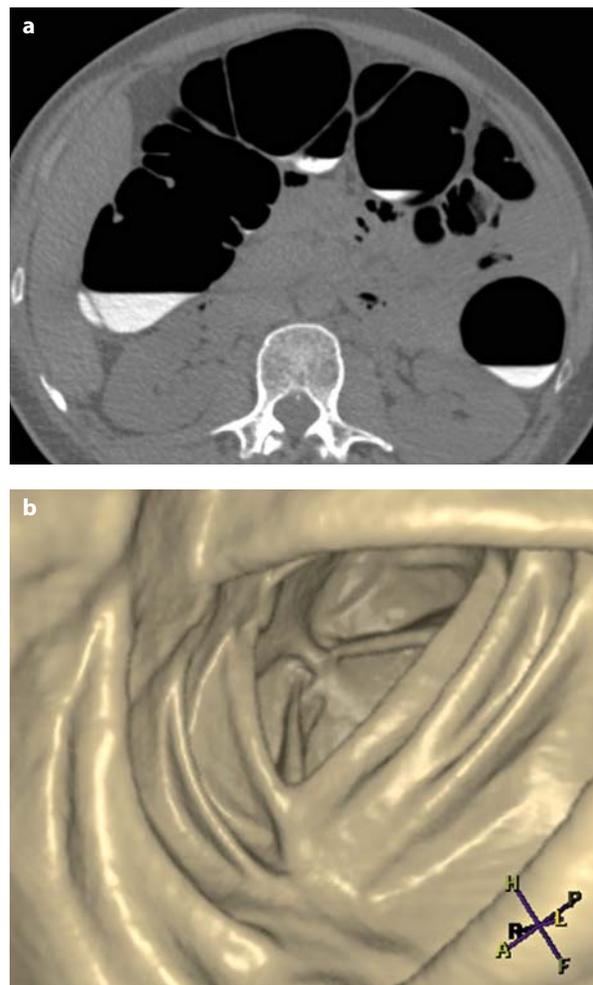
a, b. CT colonography after extensive bowel preparation and fluid tagging. The transverse colon is well distended at 2D (a) and 3D (b) (virtual colonoscopy) evaluation. No abnormal finding is seen
